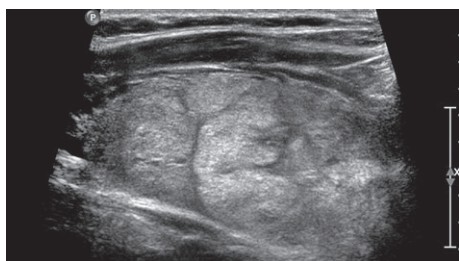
Multinodular goiter. A 43 year old patient with multinodular goiter and hypothyroidism. Sagittal ultrasound the right lobe showed an enlarged thyroid gland with multiple iso- to hyperechoic nodules of variable size, however similar in appearance.
